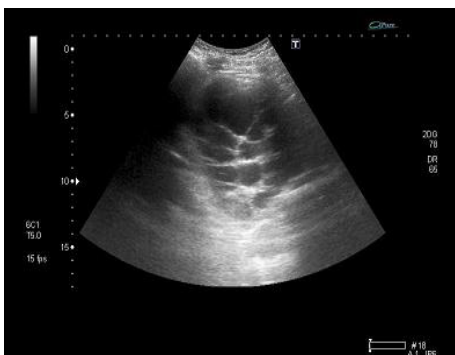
Echocardiography shows multilocular cystic lesions with posterior acoustic enhancement near the left ventricle.
